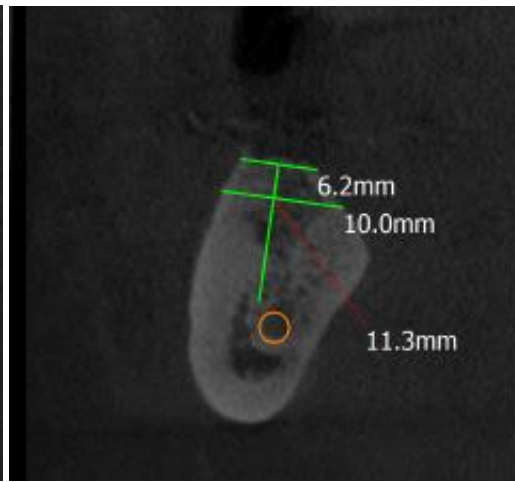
CBCT at the crest at 6 months
